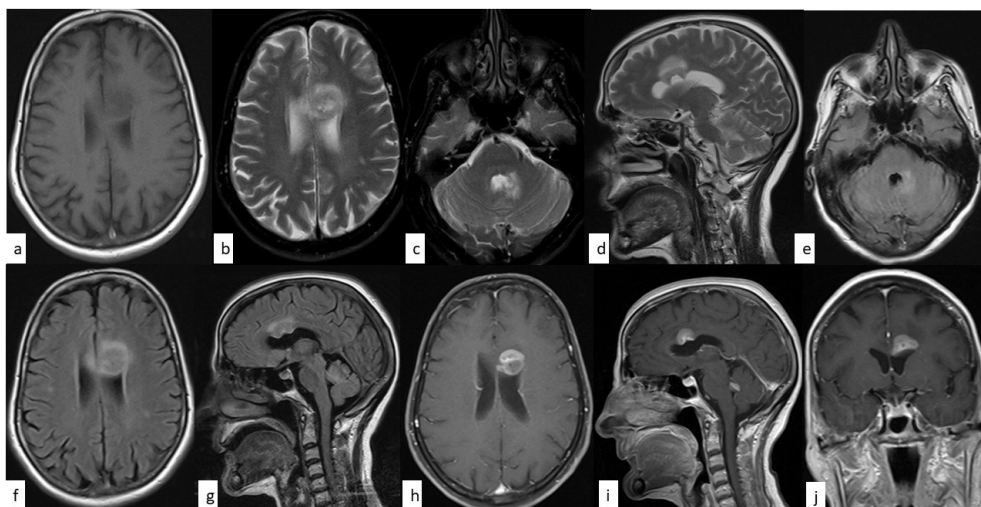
Initial brain MRI in (May 2019), demonstrating two periventricular lesions (supratentorial and infratentorial) with low T1 signal intensity (a) and high T2/FLAIR signal intensities (b–g). Gadolinium-enhanced T1W images showing homogenous enhancement (h–j).
